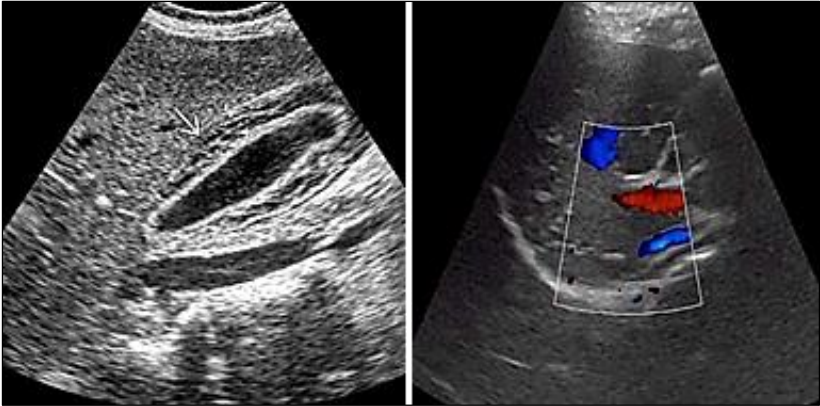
Ultrasound finding of hepatitis
